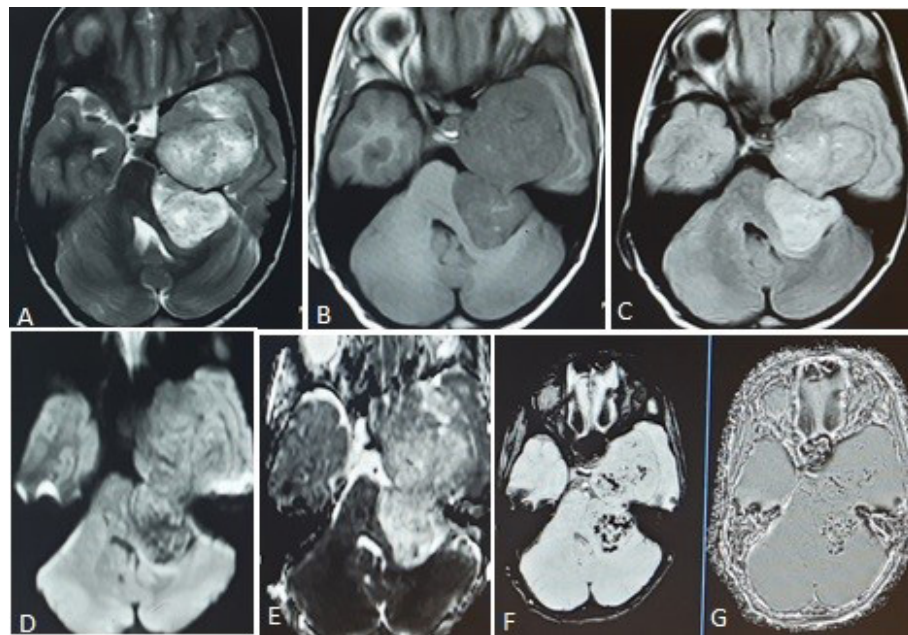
Schwannoma. (A) axial T2W, (B) axial T1W, (C) axial FLAIR, (D) DWI, (E) ADC map, (F) ITSS in SWI and (G) SWI phase images show a large left trigeminal schwannoma
